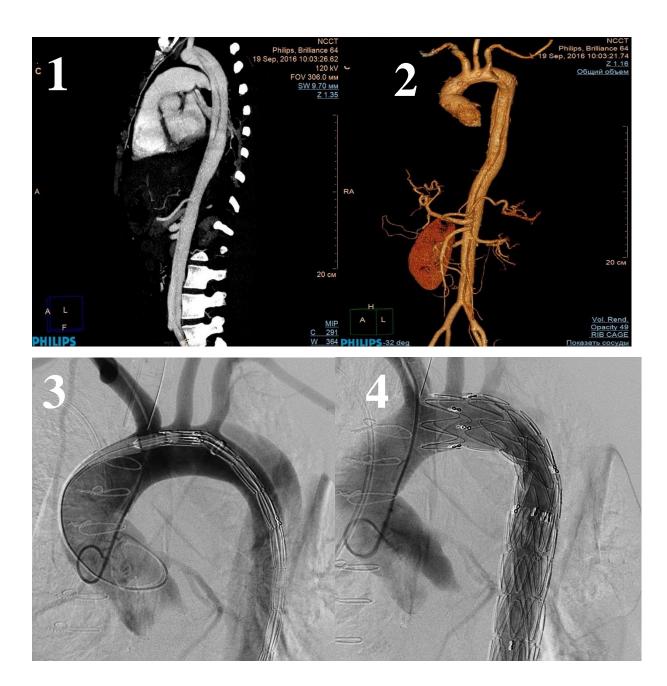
Implantation of two stent grafts in the thoracic region of the descending aorta. 1-2. Aortic dissection from the ostium of the left subclavian artery (CT-angiography). 3. Aortography and stent graft positioning. 4. Aortography after stent grafts implantation.
